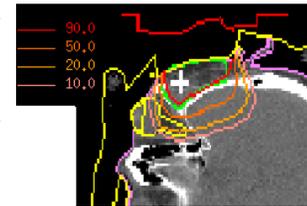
PBRA-calculated dose distribution for custom electron bolus (red line floating above CT image of skull) treatment plan with skin collimation present. Again the 90% isodose line (red) conforms to the distal end of PTV (green line) but less dose is delivered to the orbit (yellow contour inside CT image of patient head).
